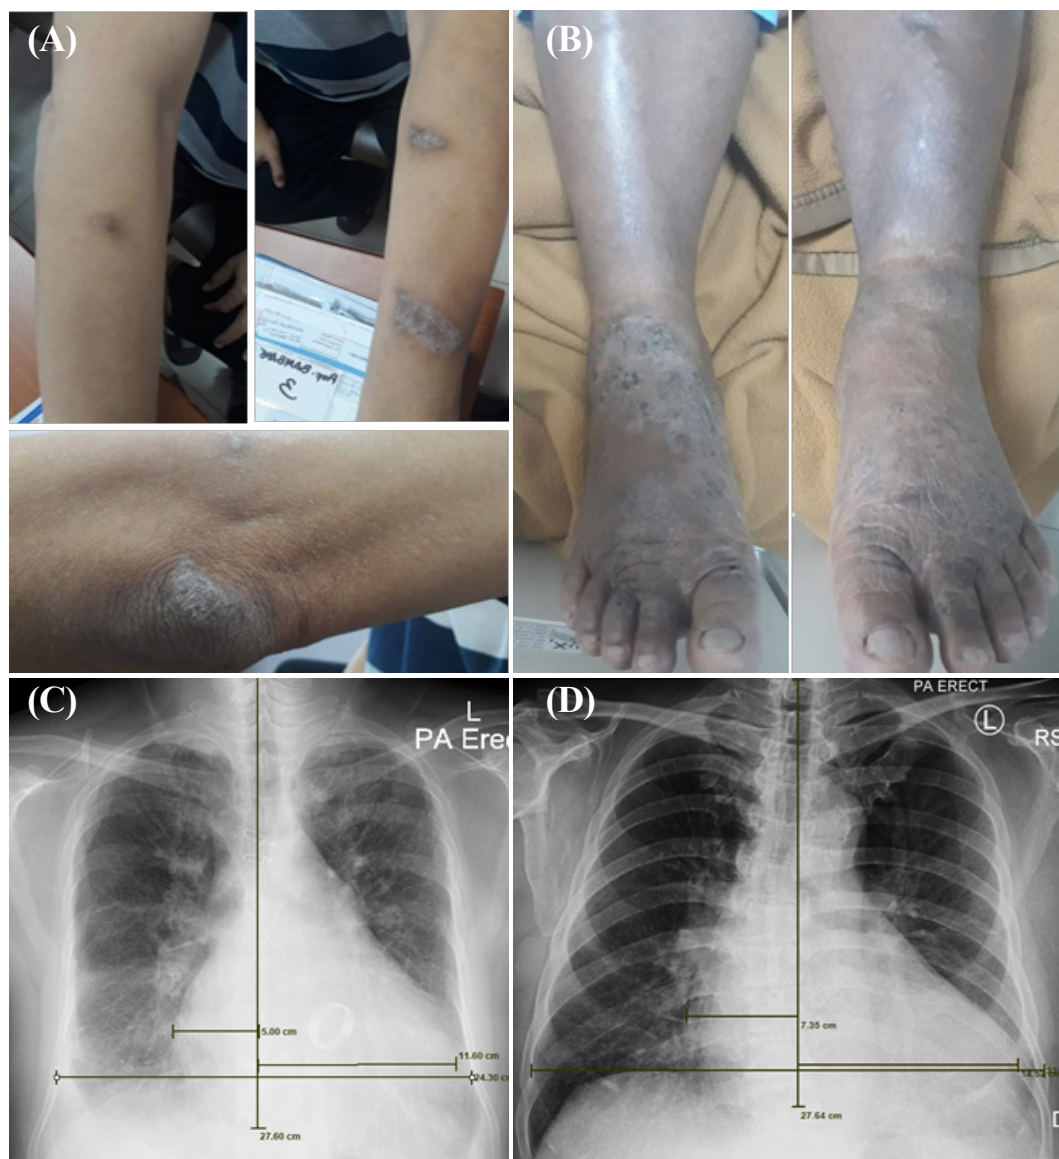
(A) skin lesions in the first patient: scales and plaques over the extremities; (B) skin lesions in the second patient: plaques over the feet; (C) chest radiograph of the first patient: enlarged heart and bilateral pulmonary congestion; (D) chest radiograph of the second patient: enlarged heart and mild congestion.
